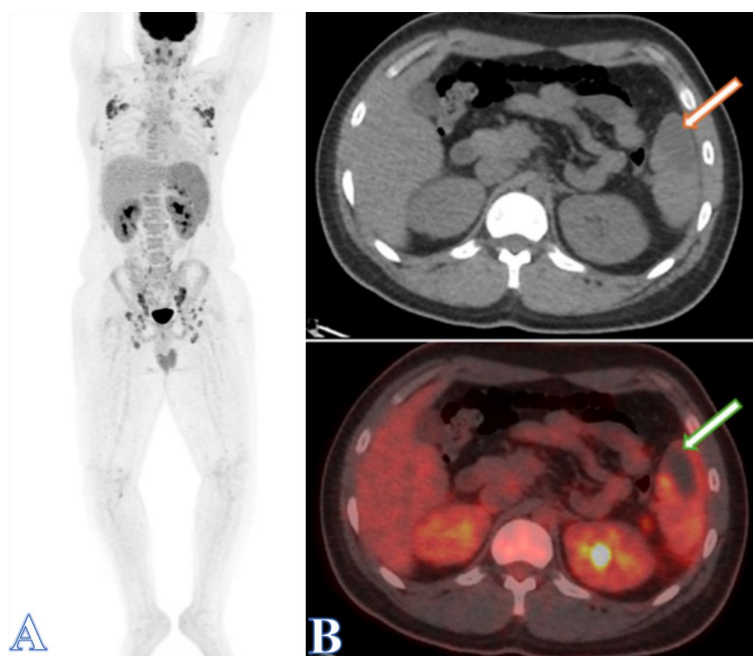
Showing: (A) Maximum intensity projection (MIP) images of a PET scan revealing increased FDG uptake in all lymph nodes and spleen as well as (B) axial CT and Fused PET/CT images showing a photopenic-hypodense area in the spleen (arrows) representing infarction.
